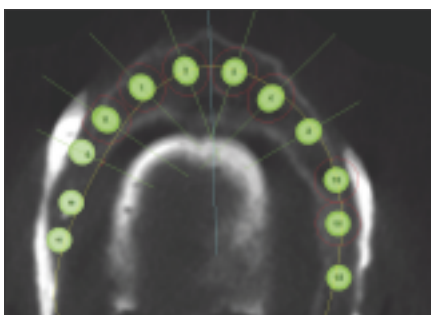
The axial view of a CBCT shows the team the availability of spacing between adjacent implants.
